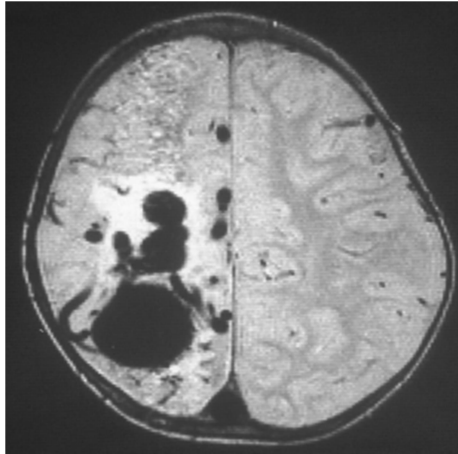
Brain magnetic resonance imaging (MRI) depicting a CAVM of a 9 month old child (Bayrak-Toydemir *et al.*, 2004).
